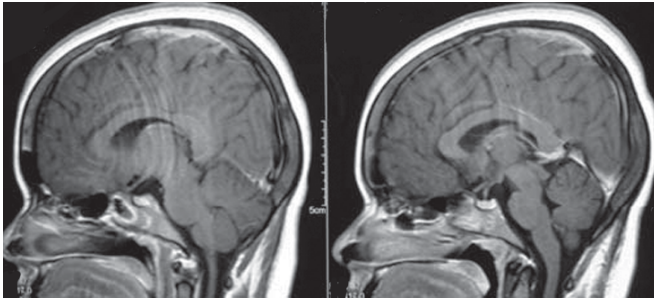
MRI showing hyperdensity along the course of the vein of Labbe, suggestive of cortical venous thrombosis
